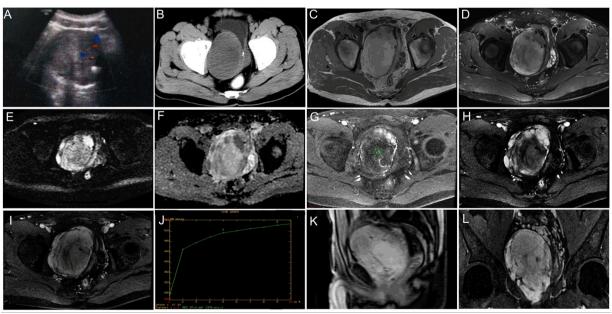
Imaging findings of patients. (A) Pelvic ultrasound revealed a hypoechoic irregular mass arising from the prostate. (B) CT showed that the lesion was hypodense with calcification in it. (C) MRI revealed a large heterogeneously hyperintense mass with a well-defined border involving the prostate on axial T1WI. (D) The mass was hyperintense (some part was hypointense compared with T1WI) on axial fat-saturated T2WI. (E and F) The mass was also hyperintense on DWI and ADC images. (G) Enhanced MRI showed that the lesion had a little enhancement on immediate post-contrast images. (H and I) The mass had a significant retention of contrast on 5- and 10-min-delayed images. (J) The time-signal intensity curve was of increasing type. (K) The sagittal T2WI showed that the mass was between the bladder and the rectum. (L) Coronal imaging of enhanced T1WI.
